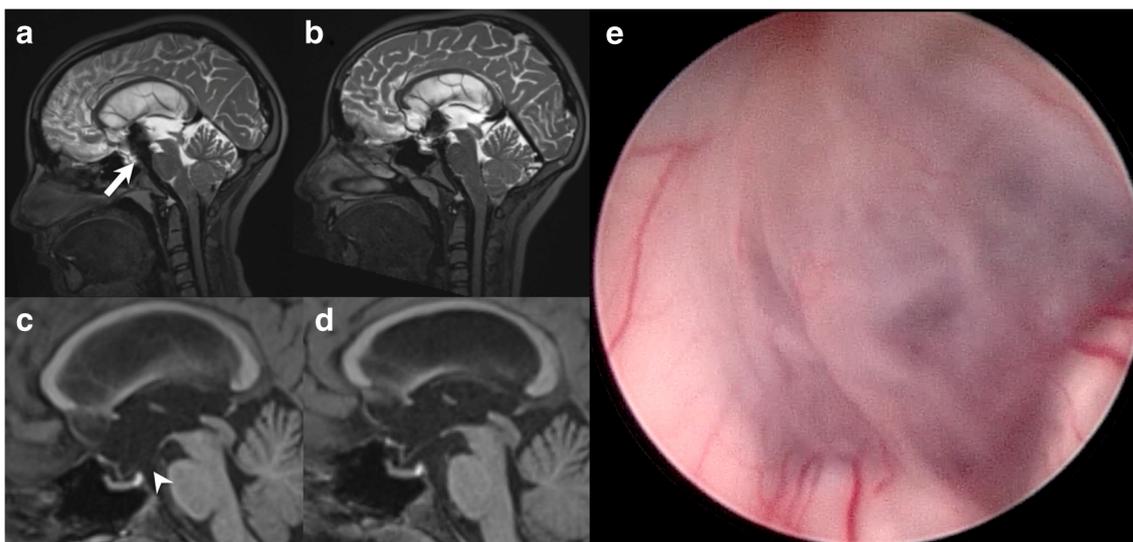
Mid-sagittal 3D-SPACE T2-weighted MRI before (a) and after (b) surgery showing prominent flow void through the floor of the third ventricle.; white arrow, pseudo-flow void artifact. Mid-sagittal T1-weighted MRI before (c) and after (d) surgery showing position of the third
